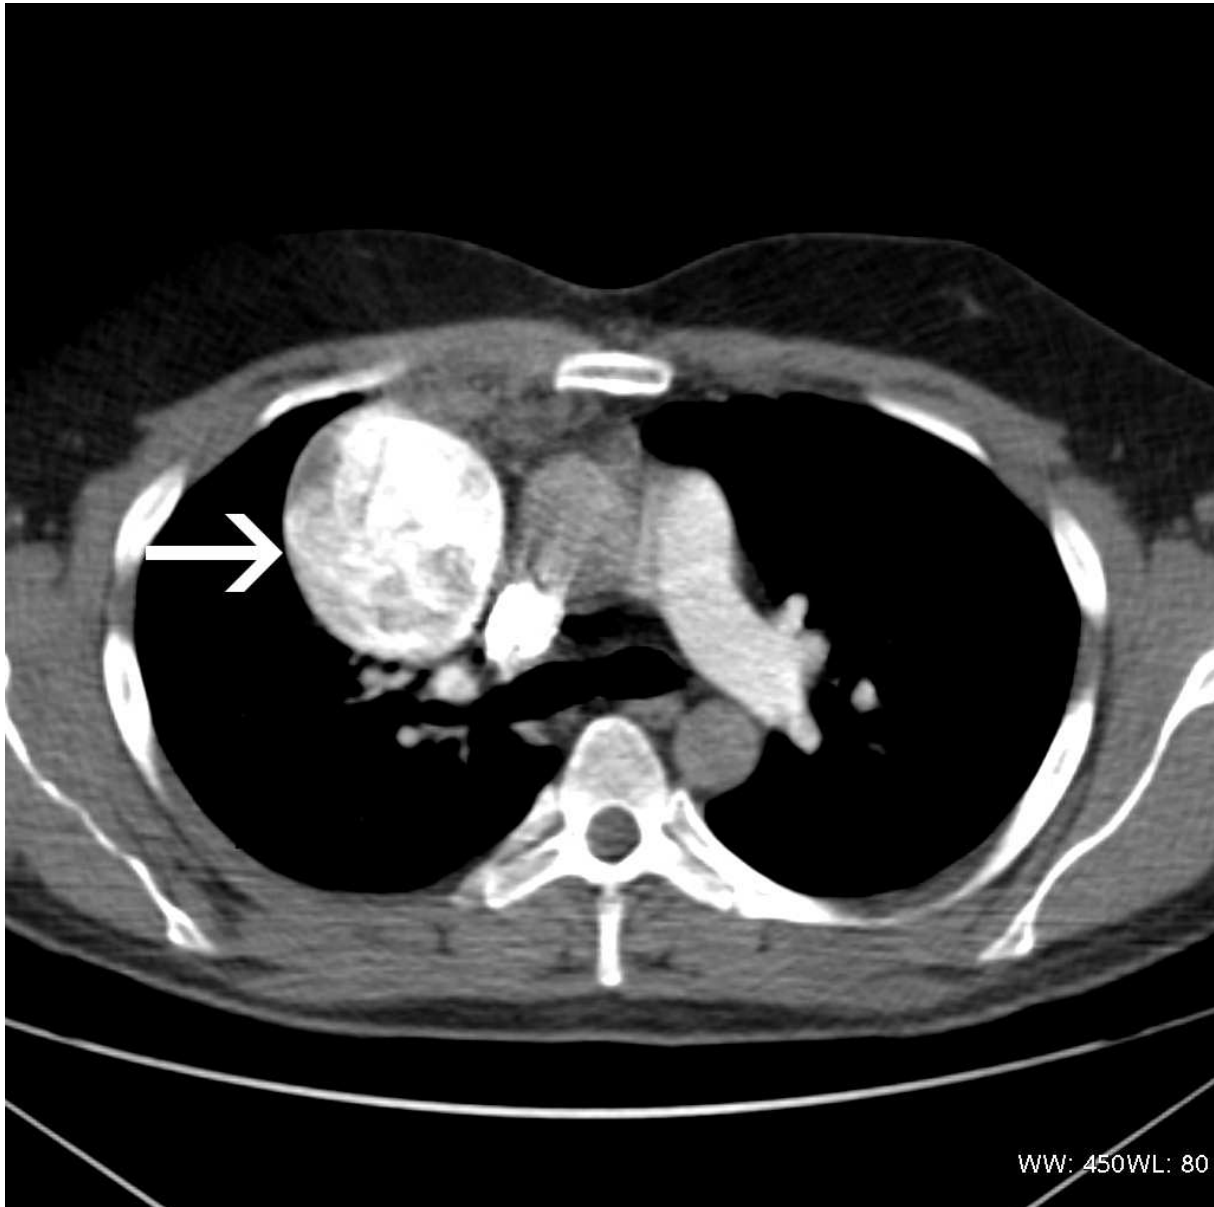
Axial scan, CT. Saccular aneurysm of SVC (arrow)
